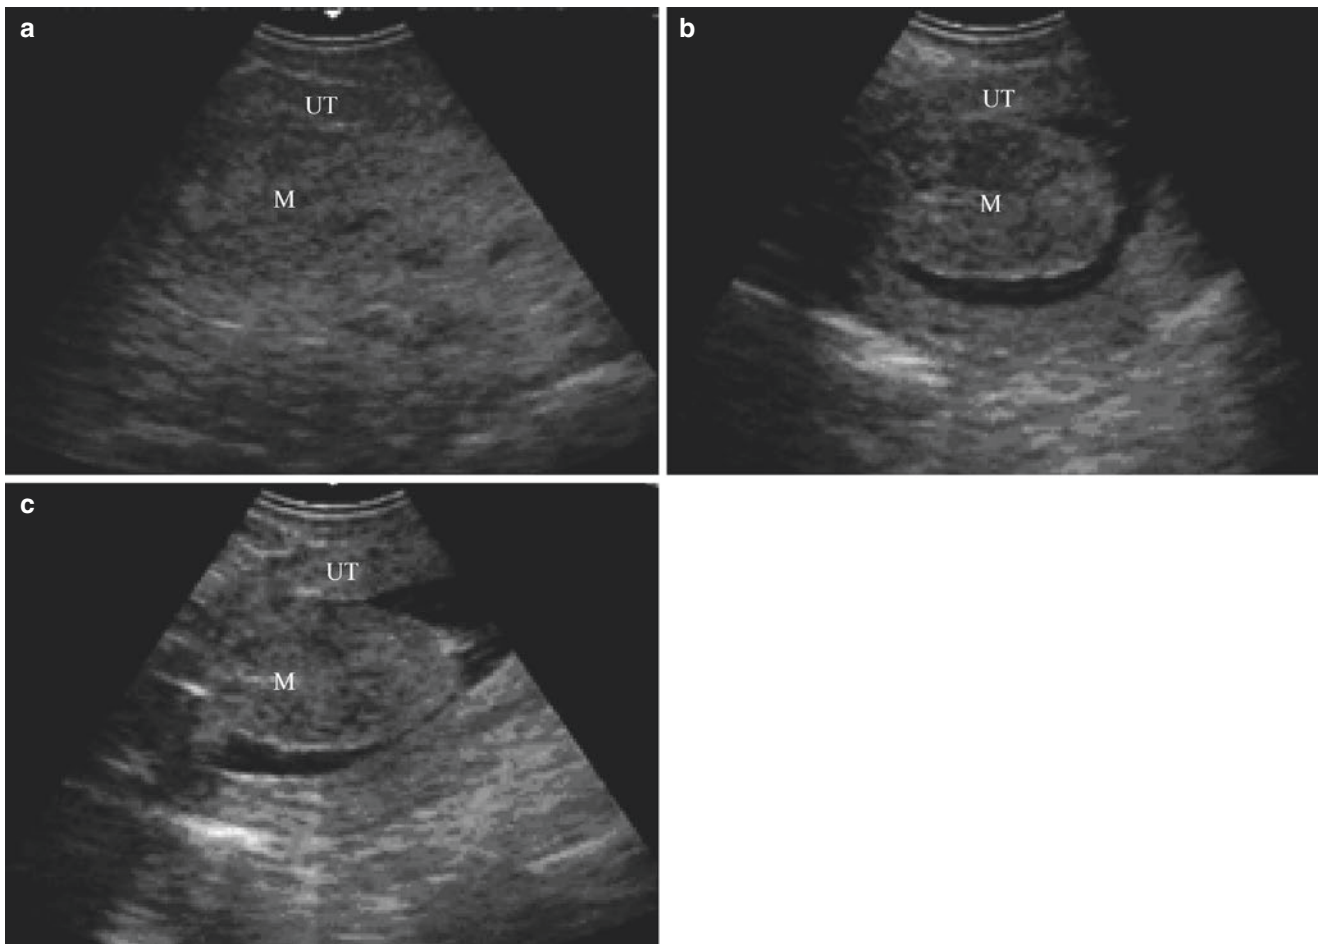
Sonohysterography of intramural uterine myoma extruding to the cavity. (a) The patient is 34 years old, and the sonogram shows the occupation in the uterine cavity. (b) After injection of the contrast agent, the hypoechoic mass in the uterine cavity is attached to the right
